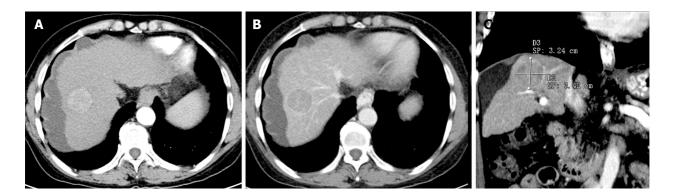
Contrast enhanced computed tomography of one typical patient in this study. A: One lesion in the right lobe shows arterial phase hyperenhancement; B: The lesion demonstrates typical rapid washout feature; C: Capsule of the tumor can be observed. B and C also demonstrate the measuring method used in the study.
